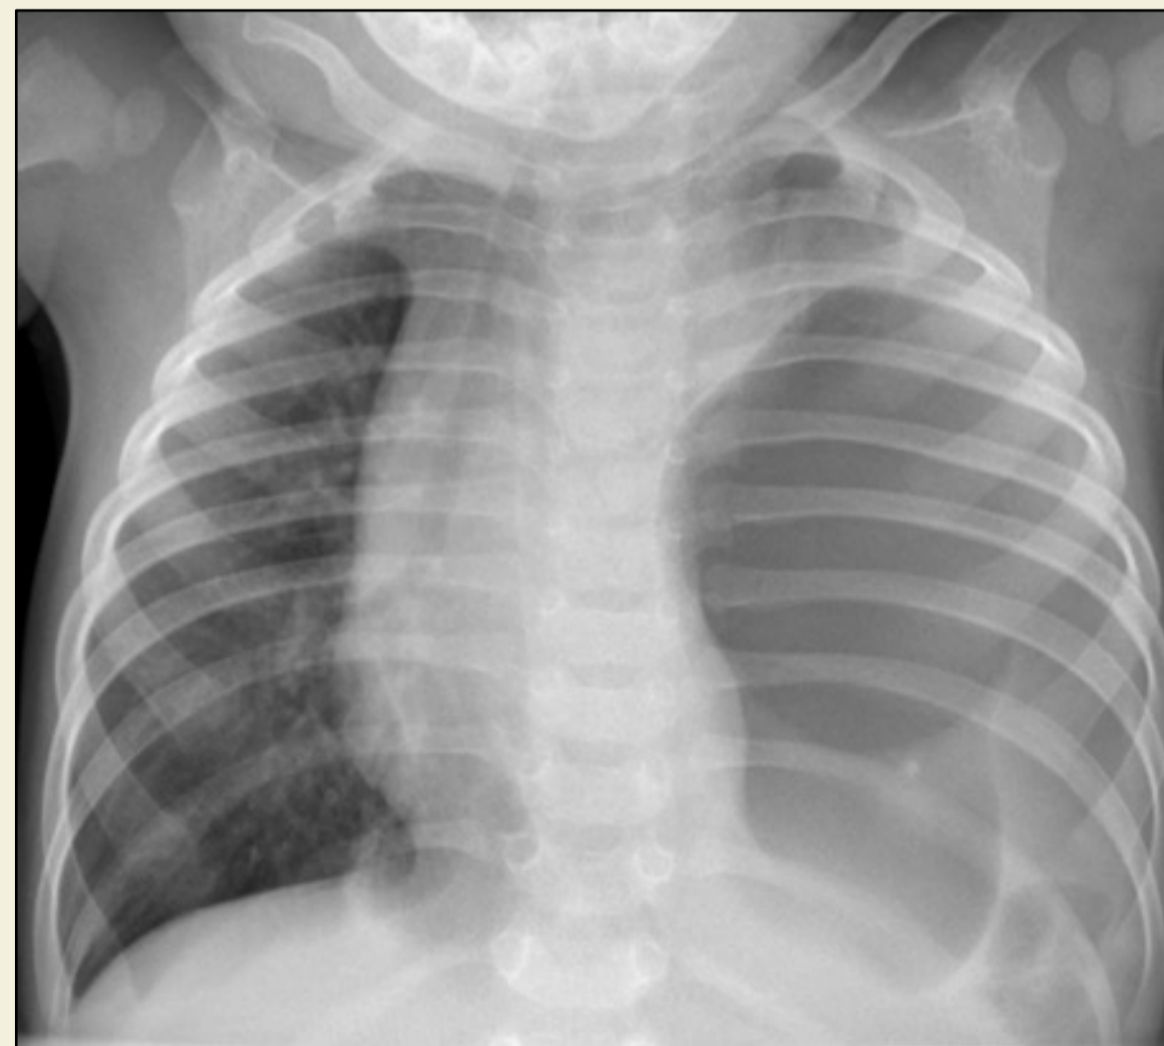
Chest x-ray on arrival showed a huge lucency in left hemithorax with a marked mediastinal shift
